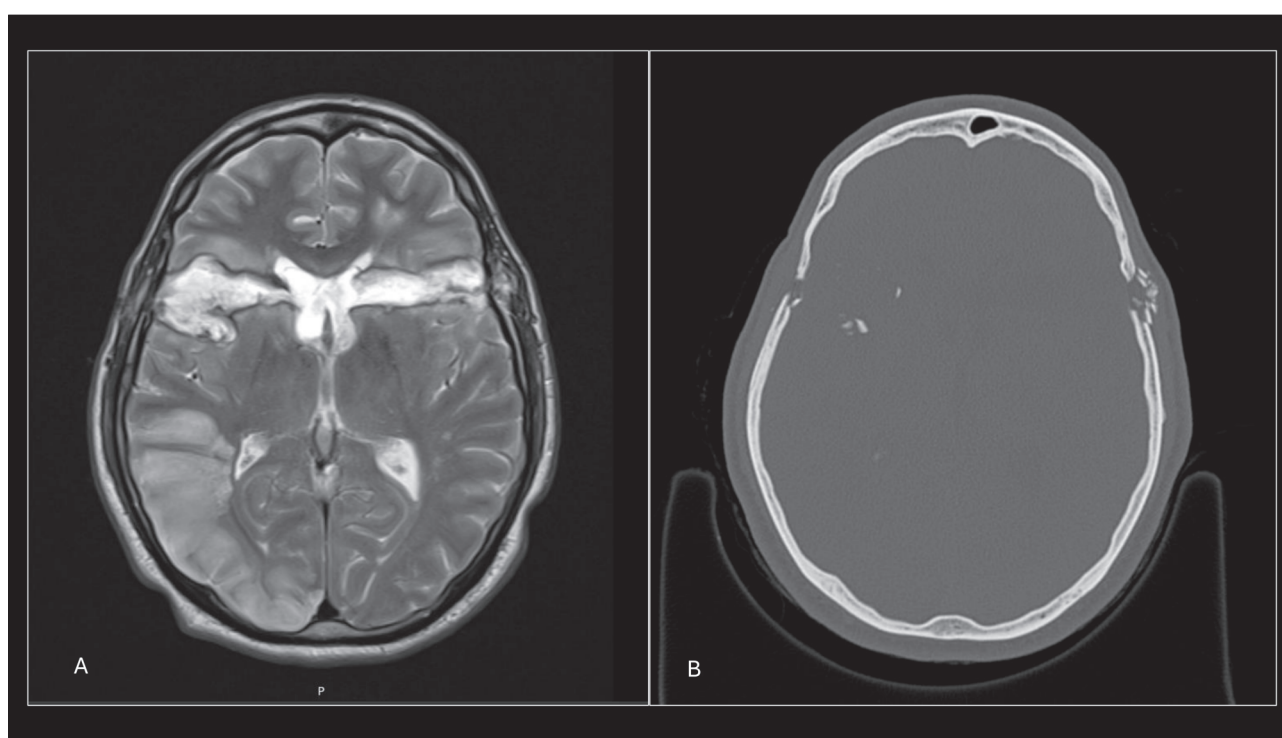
A) Cerebral magnetic resonance imaging (T2WI) revealing the bullet trajectory with fronto-opercular parenchymal hemorrhage; B) Cerebral computed tomography scan showing the entry and exit points of the projectile.
